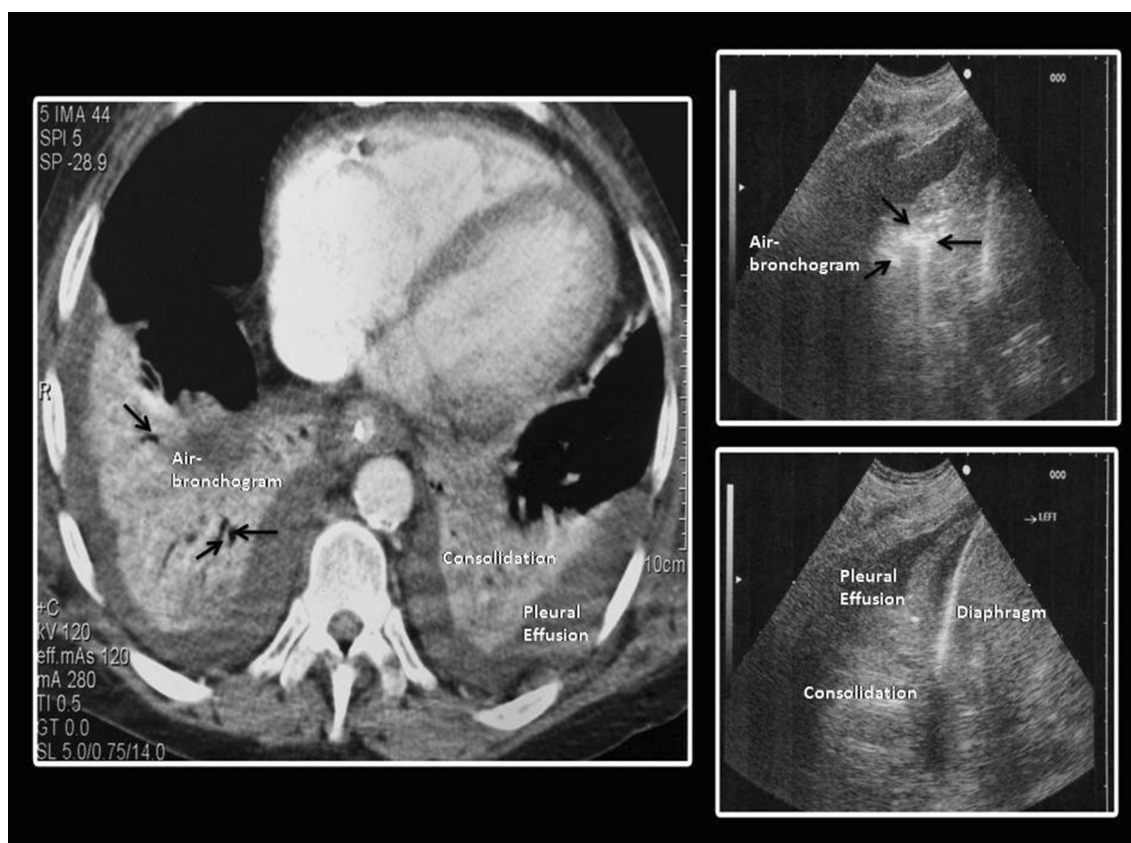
Left multiple detector computed tomography after intravenous contrast material revealed bilateral consolidations with air bronchogram (arrows), associated with pleural effusions. Right
